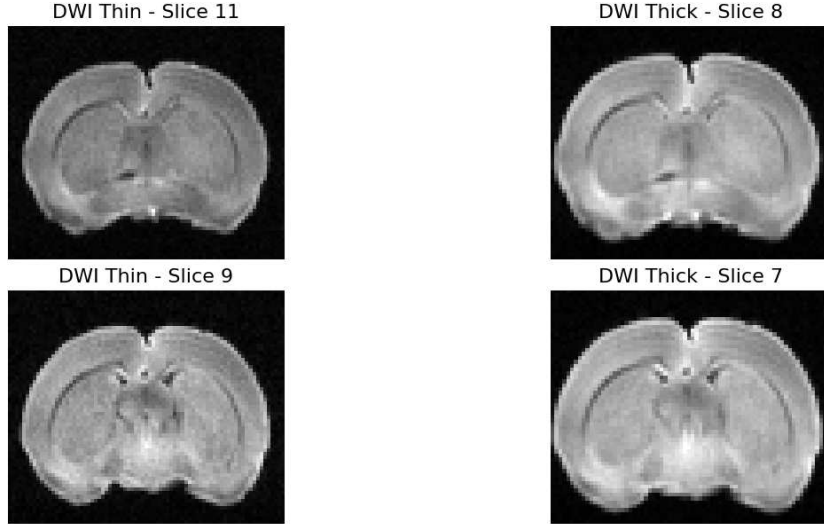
First diffusion direction of the DWI at $b = 3500 \text{ s/mm}^2$ acquired with slice thickness 0.2 mm (left) and 0.75 mm (right).
